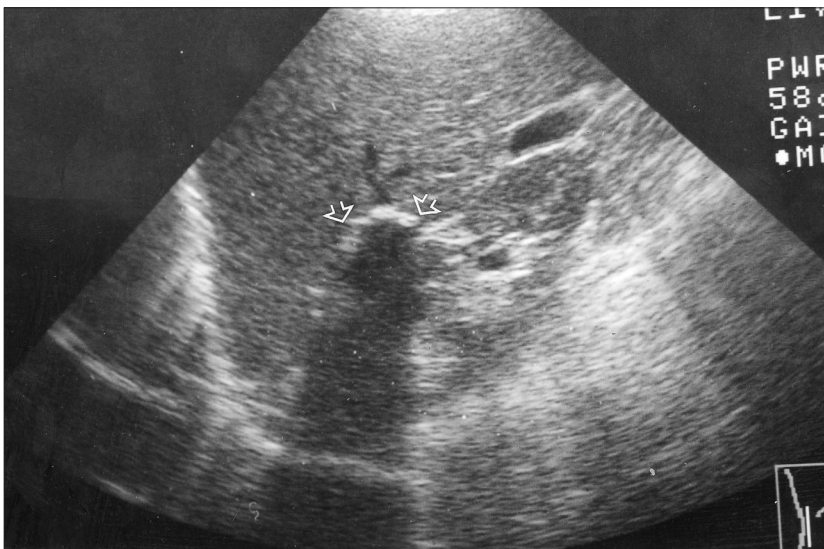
Ultrasound of the liver shows a hyperechoic lesion located in the right lobe (arrows), with an associated intense acoustical shadowing cone caused by calcification.
